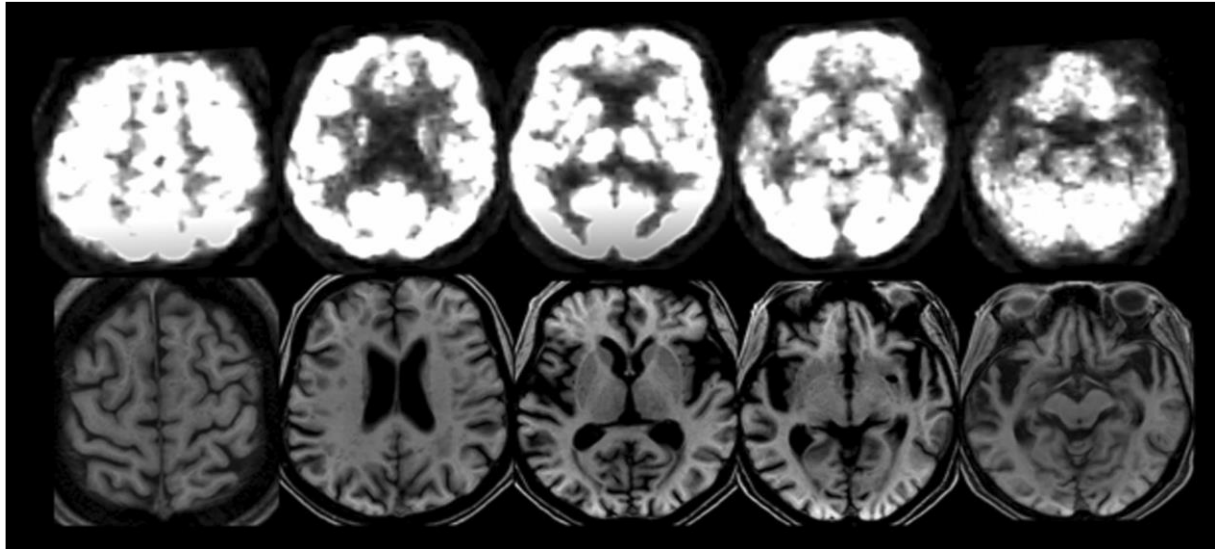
² Upper row: 18FDG-PET scan showing bilateral hypometabolism in the anterior temporal cortex. The metabolism of the orbitofrontal cortex as well as the caudate nucleus and thalamus is bilaterally normal. Lower row: T1-weighted MRI showing severe bilateral anterior temporal lobe atrophy with relative sparing of the frontal, parietal, and occipital lobes
